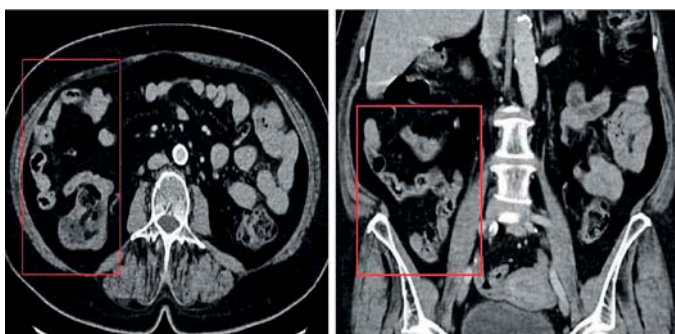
Axial and coronal CT images of the ileocecal region show no visible pathological mass.
